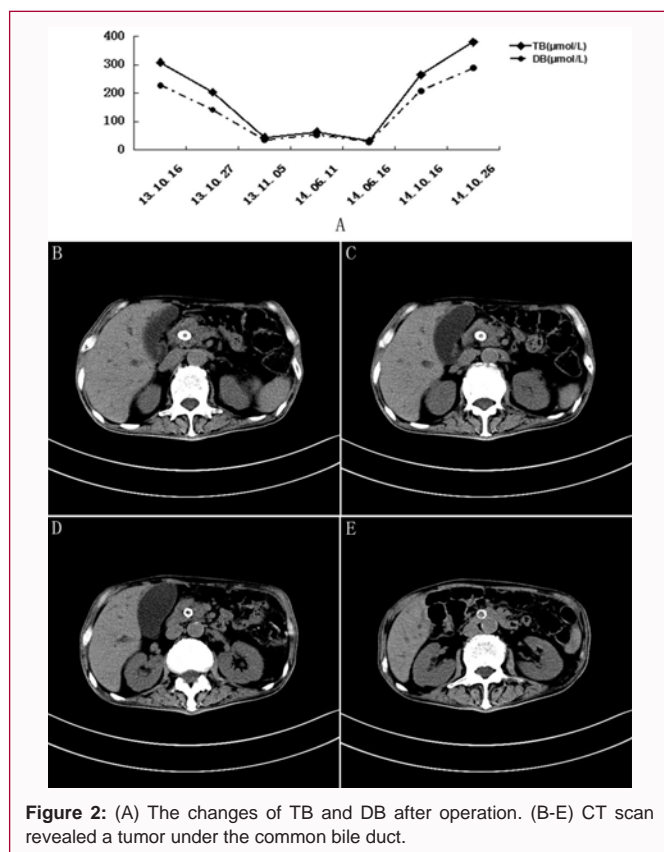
(A) The changes of TB and DB after operation. (B-E) CT scan revealed a tumor under the common bile duct.
